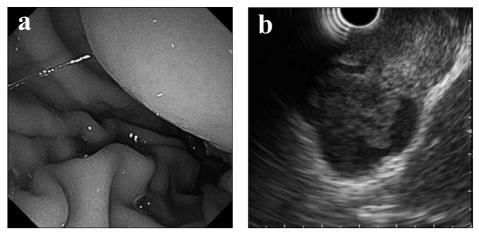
Esophagogastroduodenoscopy revealed a slightly elevated lesion in the lower body and lesser curvature of the stomach (a). Endoscopic ultrasonography (EUS) revealed an irregularly-shaped tumor 52×24 mm in size, comprising a hypoechoic part with decreased blood flow and an anechoic part as a cystic component (b).
